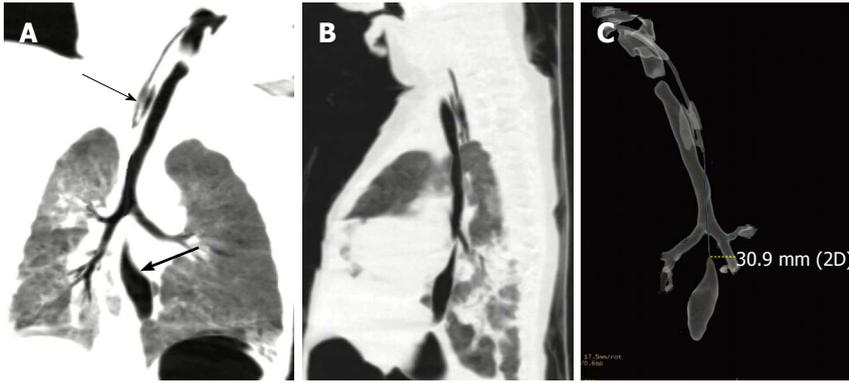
The reconstruction techniques of multidetector-row computed tomography show a case of esophageal atresia and tracheoesophageal fistula with a long inter-pouch gap. A: Coronal view of multiple planar volume reconstruction showing a long gap between the proximal pouch (thin arrow) and distal pouch (thick arrow) as well as the tracheobronchial tree with an aspirating catheter in the proximal esophageal pouch; B: Oblique sagittal view of multiple planar volume reconstruction showing a long inter-pouch distance with a tenuous fistula; C: Posteroanterior projection of transparency lung volume rendering demonstrating the distance between esophageal segments and three-dimensional anatomy of esophageal pouches and tracheobronchial tree after removal of lungs in case 3 (a 3-d old male neonate).
